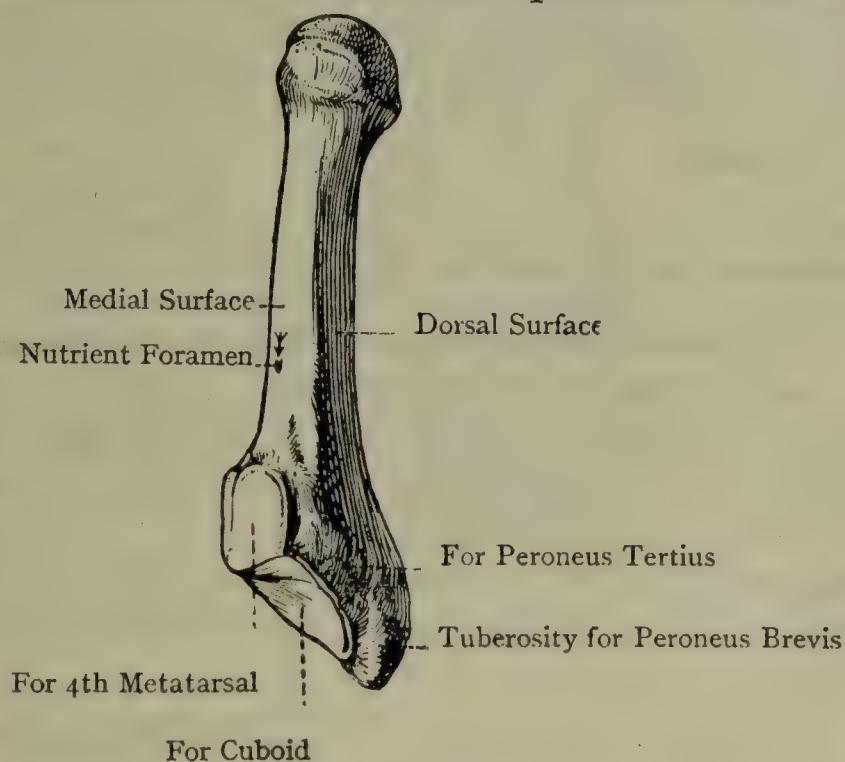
THE FIFTH RIGHT METATARSAL BONE (SUPERO-MEDIAL ASPECT).
